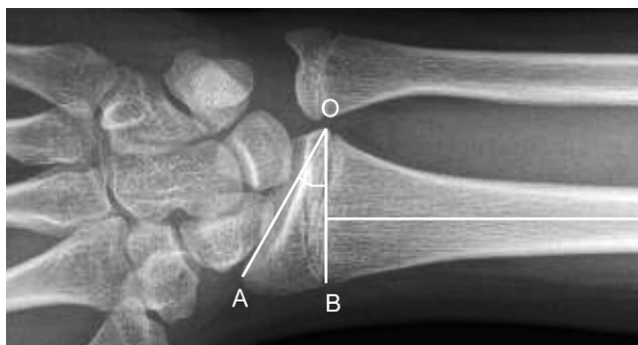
X-ray of the wrist joint in direct projection. The radioulnar angle ($\angle AOB$) is formed by line BO, perpendicular to the long axis of the radius, and line AO, drawn from the apex of the styloid process of the radius to the ulnar edge of the articular surface of the radius
